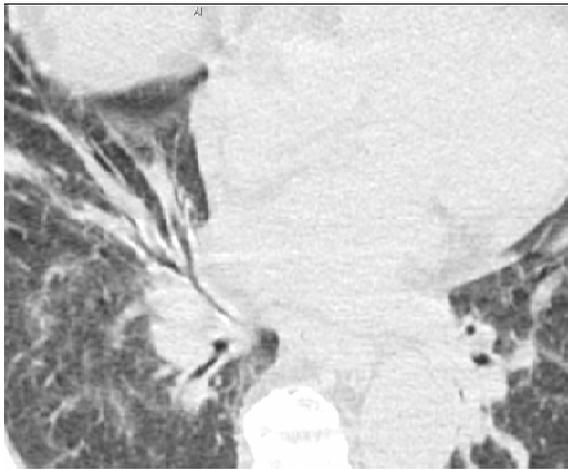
and 3B. Zoom in view of axial cut of HRCT showing bronchial wall thickening and narrowing of RML bronchus (white arrow). Bronchoscopy reveals blackish mucosa of bronchi
